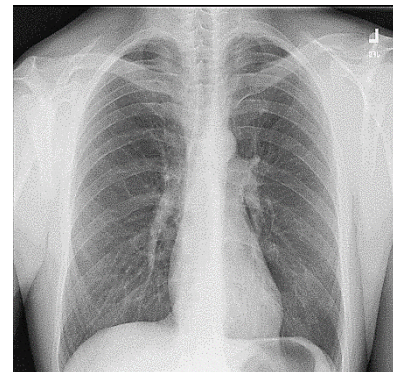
Emphysema Chest X-ray
